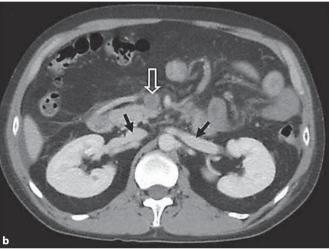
Initial abdominal CT scans at the level of the pancreatic body (a) and at the level of the renal vein (b) show thrombi within the portal vein (white arrow) and superior mesenteric vein (open arrow) and patent renal veins on both sides (black arrows).
